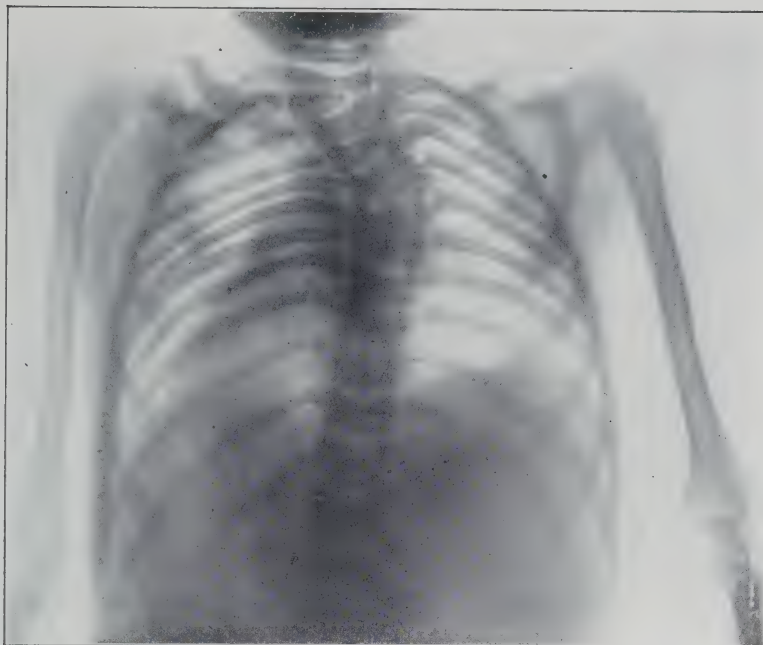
Congenital Malformation of the Vertebrae. Two wedge-shaped and several malformed vertebrae. Marked lateral curvature (torticollis). Case was recommended for operation, the futility of which is shown by the x-ray. (Original.)
